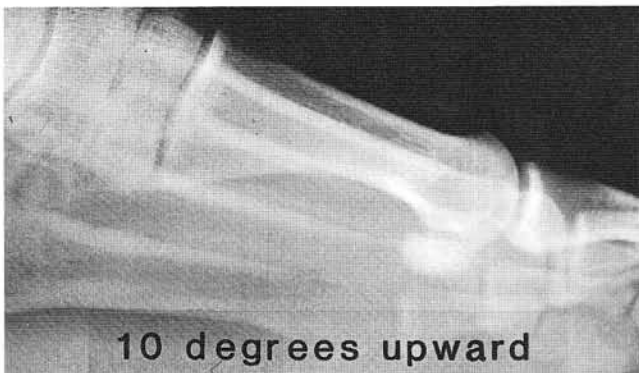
Lateral weight-bearing radiograph with the tube head directed upward 10° (dorsally). Note the amount of separation of the first and second metatarsals, while the angular relationship between these two bones remains constant.
